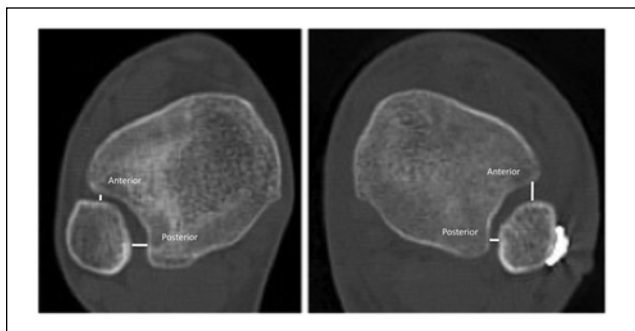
CT scans of a 20-year-old male with a Weber C fracture 1 cm proximal to the ankle joint showing increased anterior fibular-incisura distance between in the uninjured (left) and injured (right) ankle.
